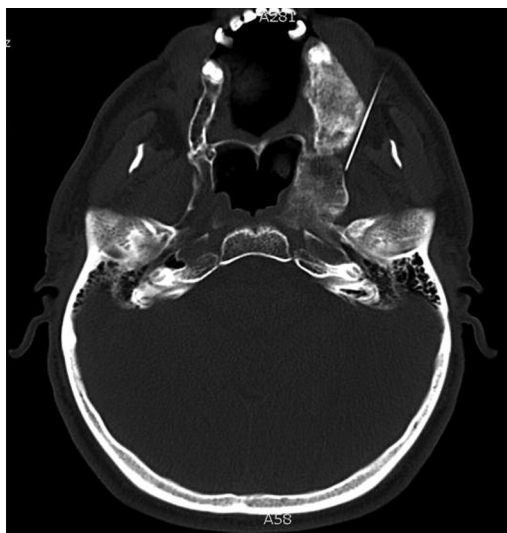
CT during Gasserian ganglion electrocoagulation in patient with craniofacial fibrous dysplasia
